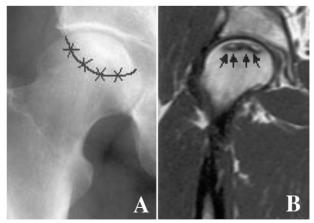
The four treatment points within the junctional zone between avascular and normal bones of the femoral head shown on radiography (A) and MRI (B) of the hip.
